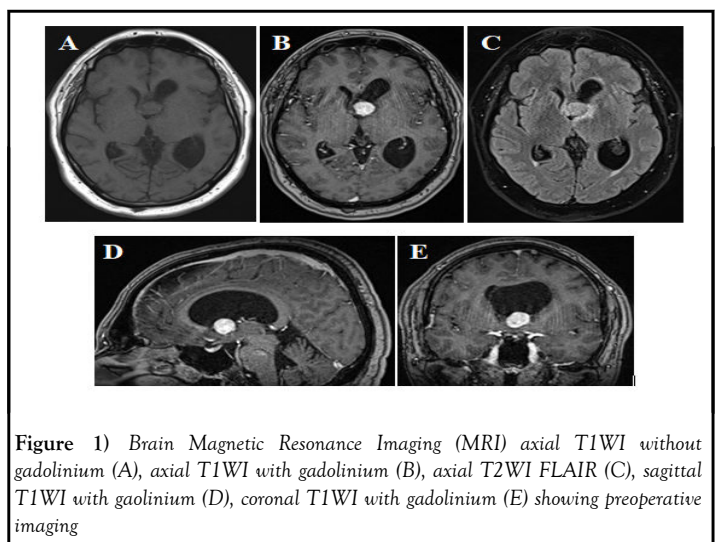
Brain Magnetic Resonance Imaging (MRI) axial T1WI without gadolinium (A), axial T1WI with gadolinium (B), axial T2WI FLAIR (C), sagittal T1WI with gadolinium (D), coronal T1WI with gadolinium (E) showing preoperative imaging
